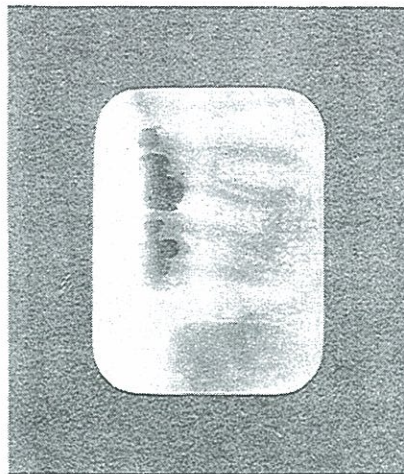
ROENTGENOGRAPHIC APPEARANCE OF THE DENTAL INFECTION PRODUCING A SEVERE NEURITIS. CASE 1120. SECOND MOLAR HAS PUTRESCENT PULP.
